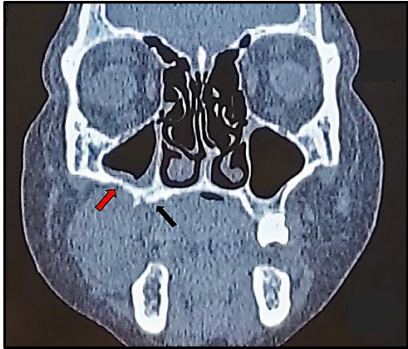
Coronal section of CT showing an expansile lesion in the right oral cavity causing thinning of the floor of the right maxillary sinus (red arrow). Associated mucosal thickening is noted along the sinus floor and medial wall. Erosion of buccal and palatal cortices of upper alveolar arch (black arrow).
